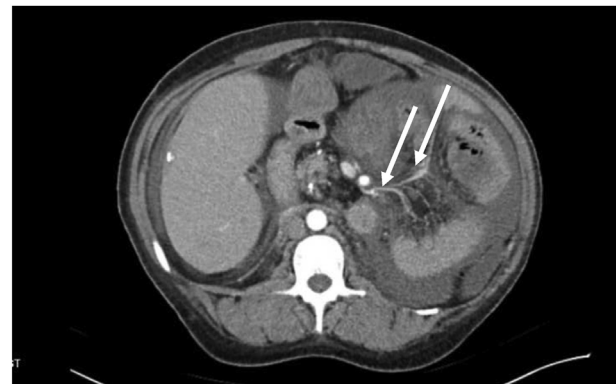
Axial view of CT abdomen showing comb sign.
